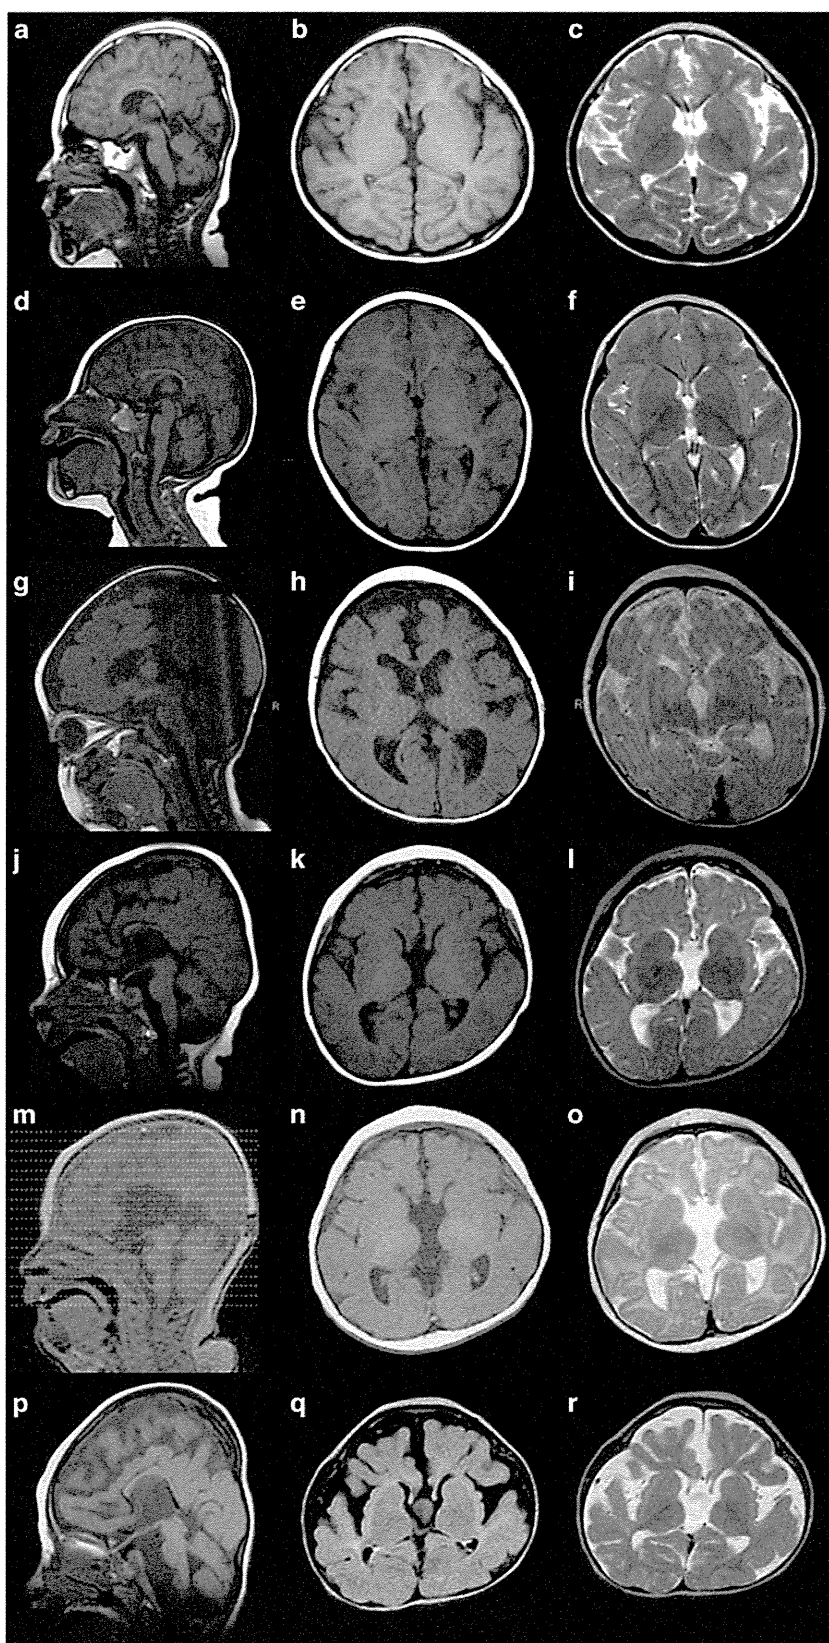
The brain MRI findings of patient 1 examined at 4 years (a–c), patient 2 examined at 3 years (d–f), patient 3 examined at 12 months (g–i), patient 4 examined at 15 months (j–l), patient 5 examined at 5 months (m–o) and patient 6 examined at 3 years (p–r). T1-weighted sagittal views (a, d, g, j, m, p), T1-weighted axial views (b, e, h, k, n, q) and T2-weighted axial views (c, f, i, l, o, r). ACC are noted in all patients. Patient 5 (m), in particular, exhibits complete agenesis of the corpus callosum. Reduced volume of the frontal lobe is seen in all patients. Prominently delayed myelination is noted in patient 3 and 4 (i and l).
